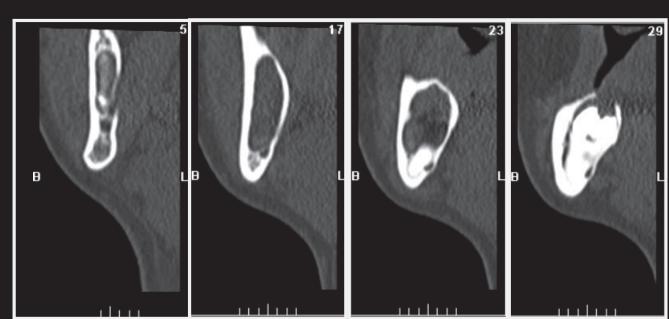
CT – Sagittal cuts.
